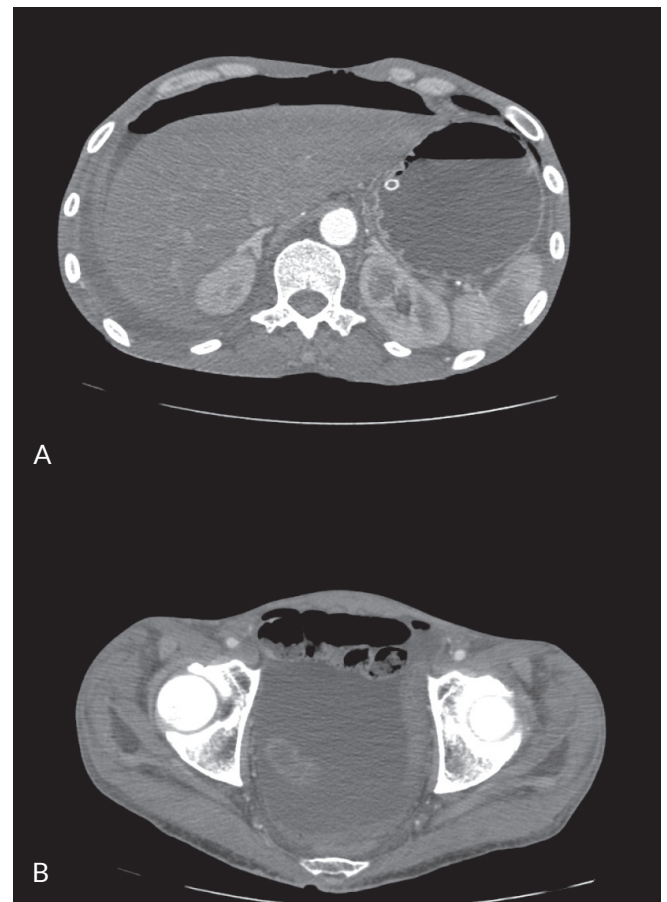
Follow-up CT on postoperative day 2. Free gas at the anterior abdominal wall (residue after recent surgery) (A), and free fluid in the abdominal cavity, mainly between the pelvic loops (B)
